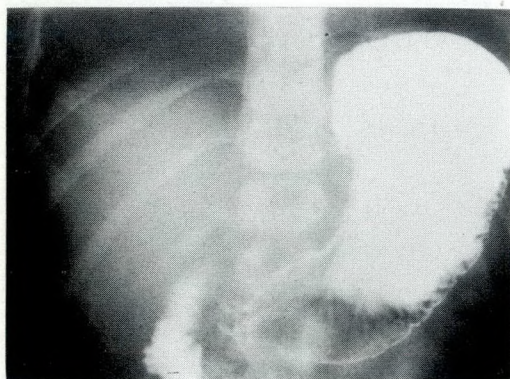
Post-traumatic pancreatic pseudocyst. Postoperative (four weeks) anteroposterior roentgenogram following ingestion of Gastrografin.
